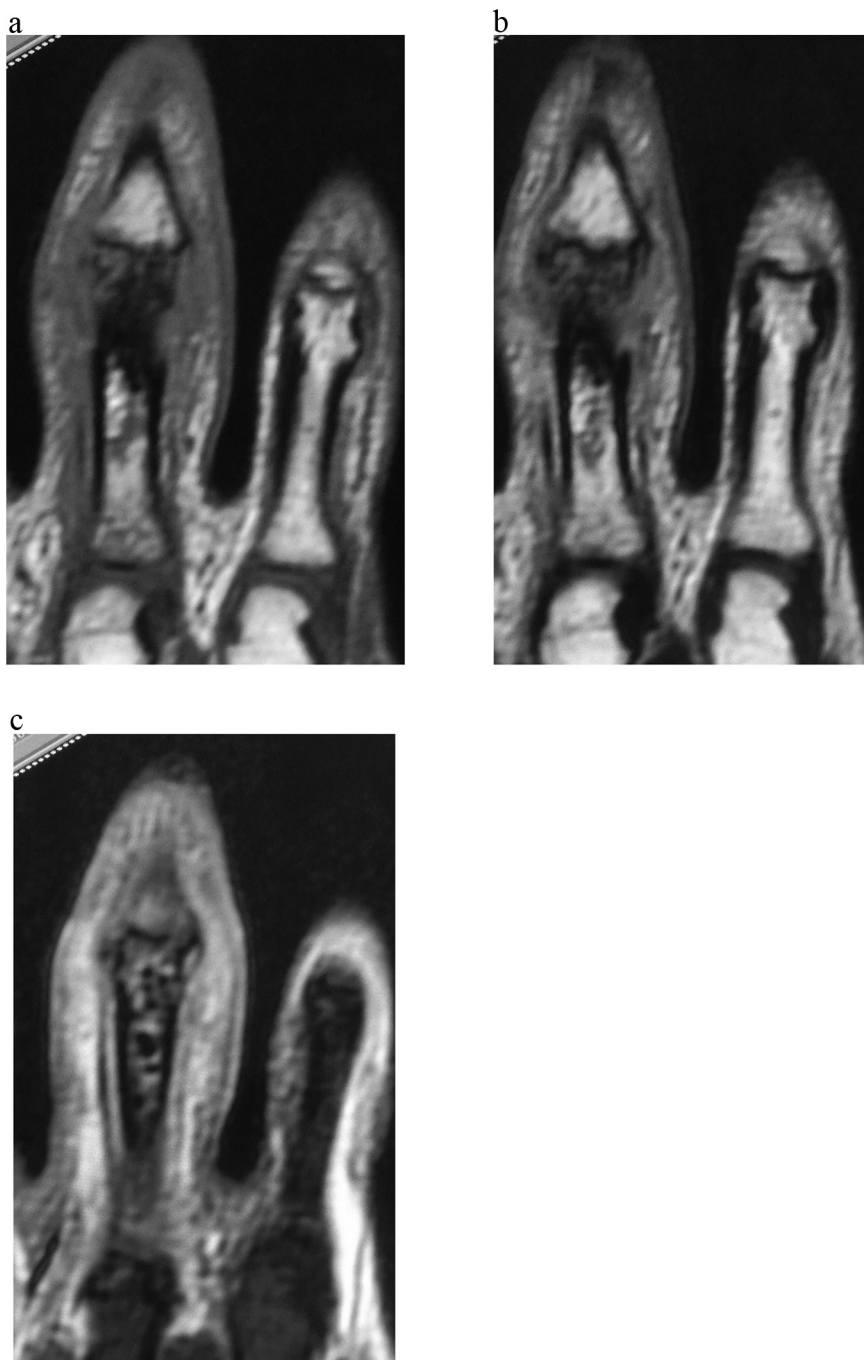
Magnetic resonance images at the first visit. Magnetic resonance images indicated osteomyelitis of the proximal phalanx.
